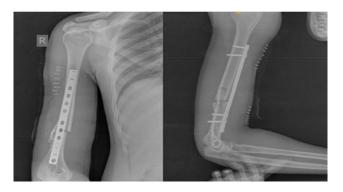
Post op X-ray (Patient 1).
